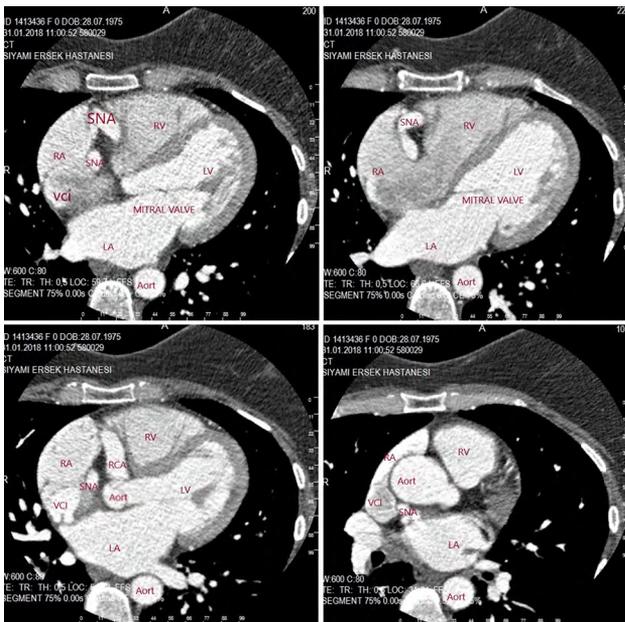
Computed tomography angiography showing aneurysmatic right coronary artery and sinus node artery. Right coronary artery is seen to run in normal diameter after giving the sinus node artery branch. RV: Right ventricle; RA: Right atrium; LV: Left ventricle; LA: Left atrium; SNA: Sinus node artery; VCI: Vena cava inferior.
